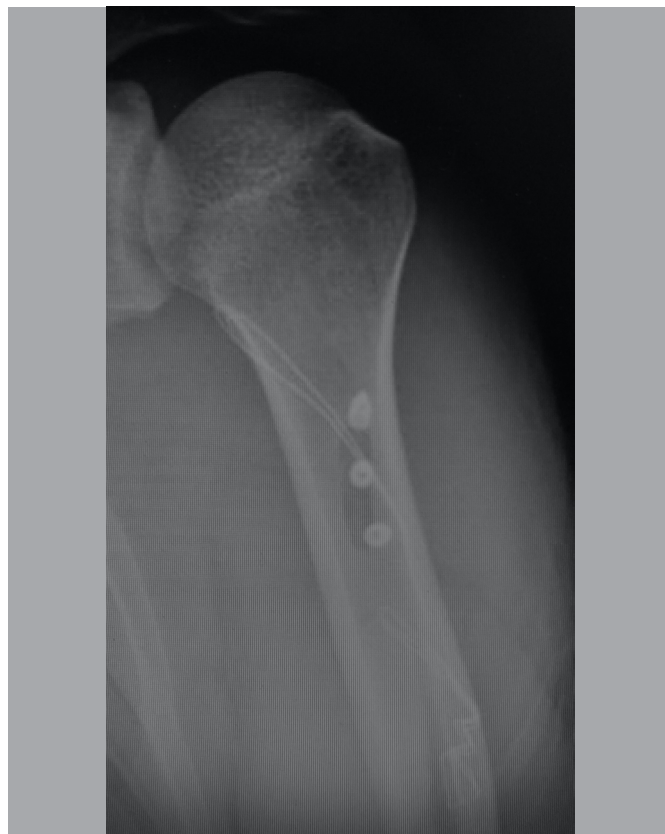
Radiography of the 3 implanted anchors and the bone tunnel.
